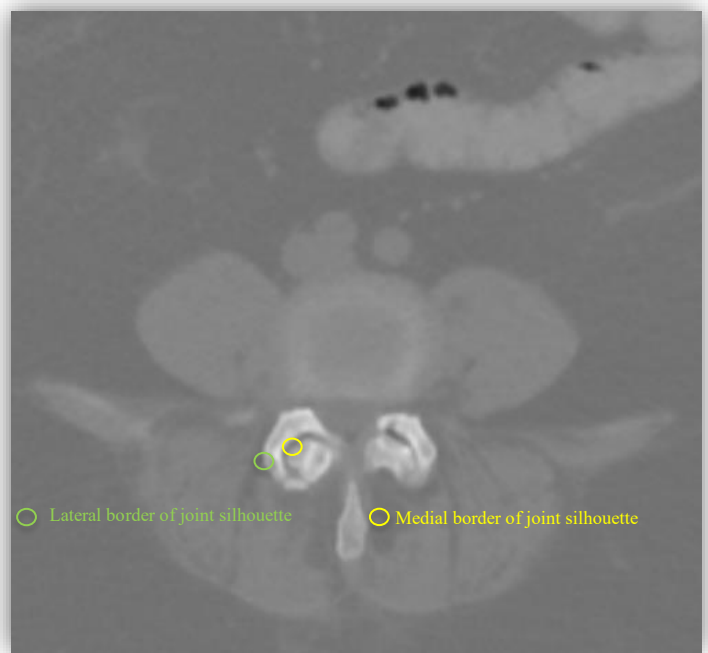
Axial CT image of the L4-L5 facet joints with significant degenerative change. The lateral border of the joint corresponds to the superior articular process. If the needle is directed towards the lateral border, the needle is less likely enter the joint space.
